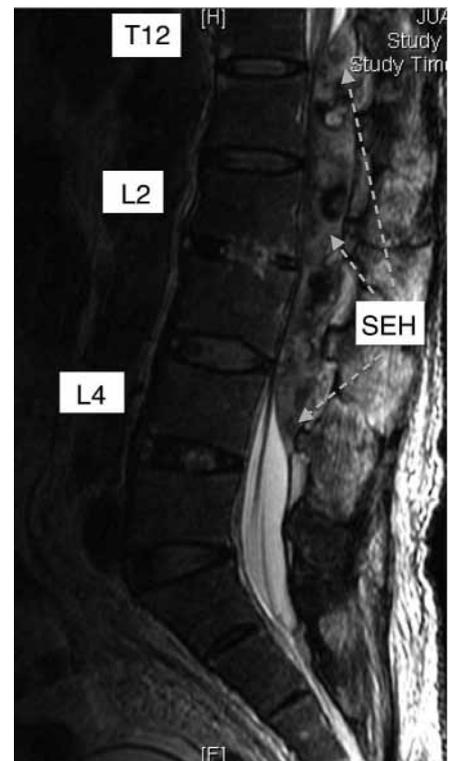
MRI T2-weighted image, median sagittal view. The black dotted arrow indicates a large epidural heterogeneous collection over the posterior aspect of the spinal canal from T12 to L4, which caused compression with effacement of the thecal sac from behind, compatible with a spinal epidural hematoma.
